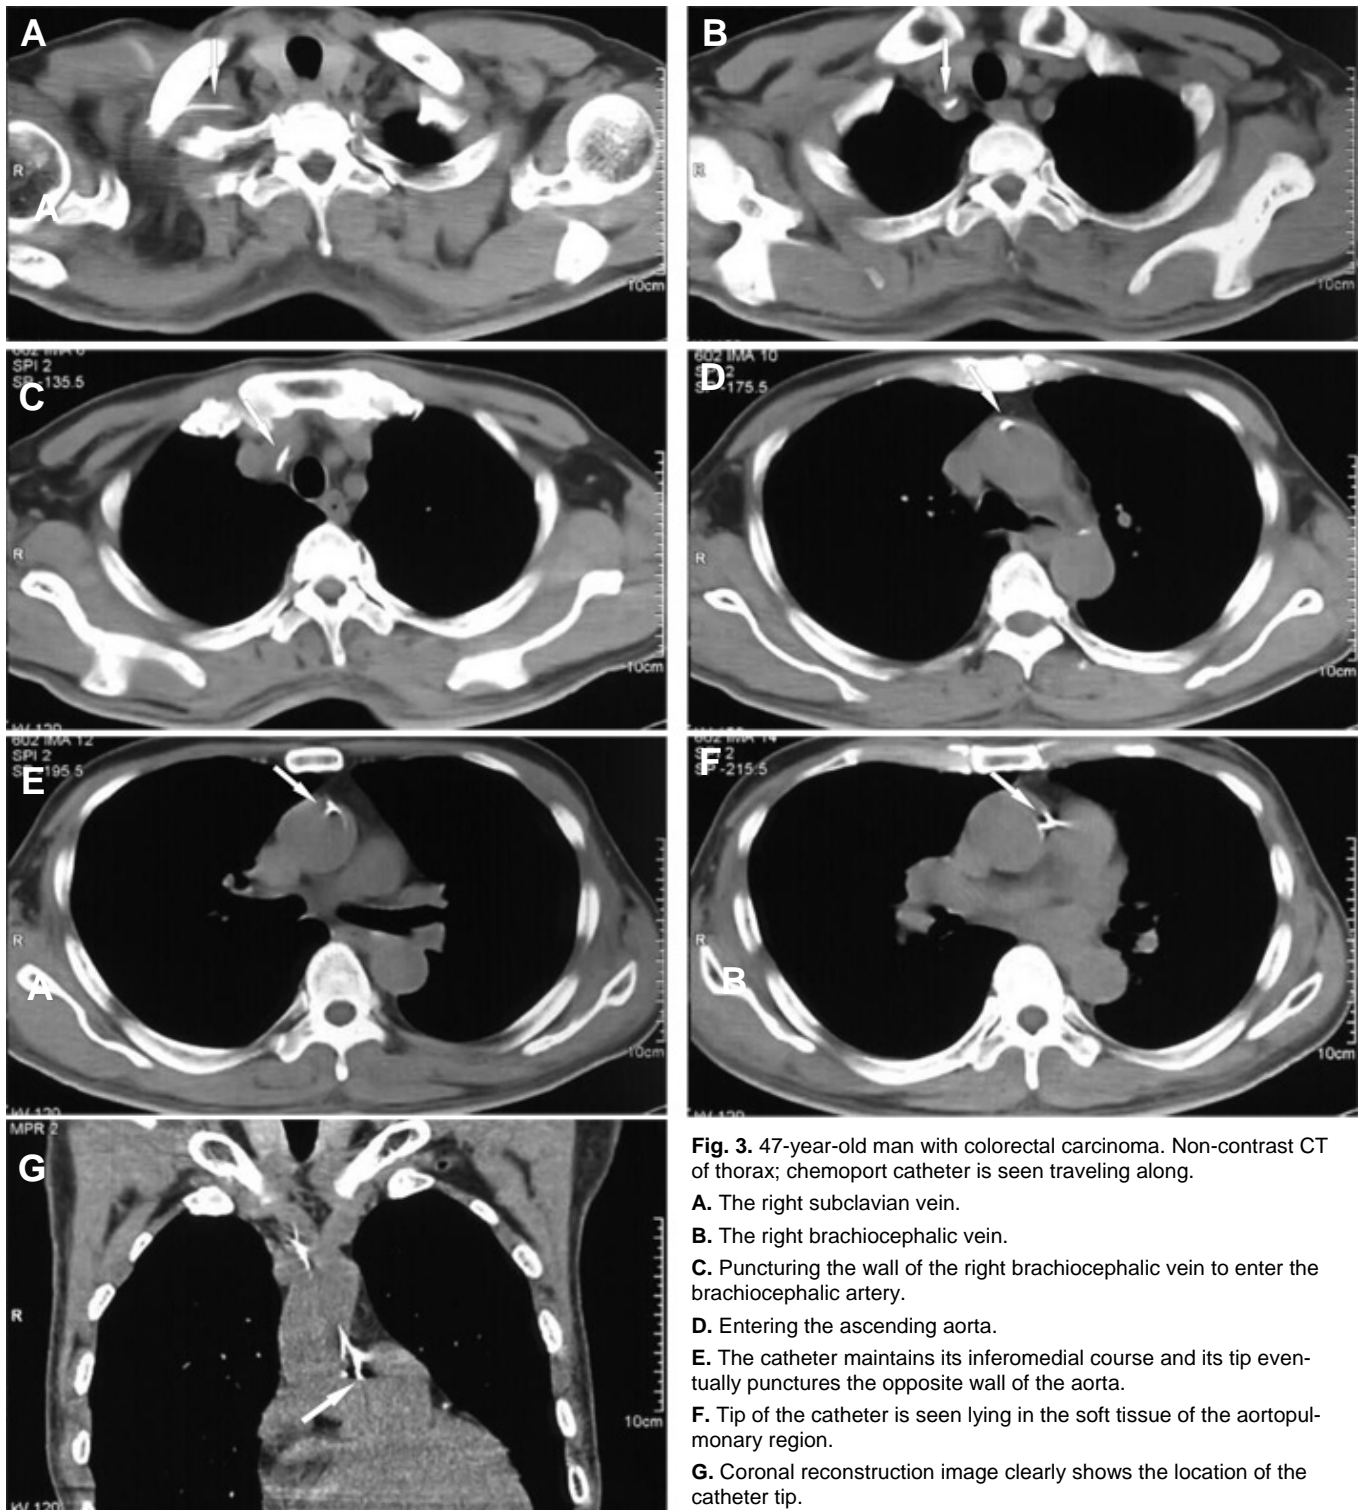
47-year-old man with colorectal carcinoma. Non-contrast CT of thorax; chemoport catheter is seen traveling along.
